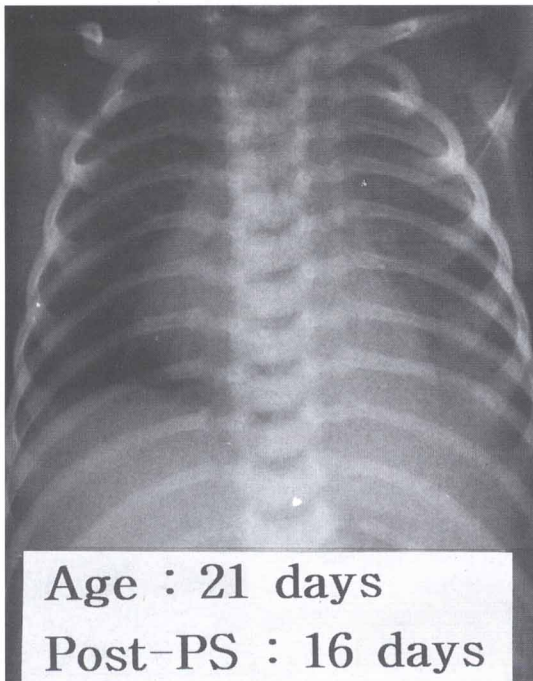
The chest roentgenogram obtained at discharge showed a much expanded lung and improved pneumonia.
